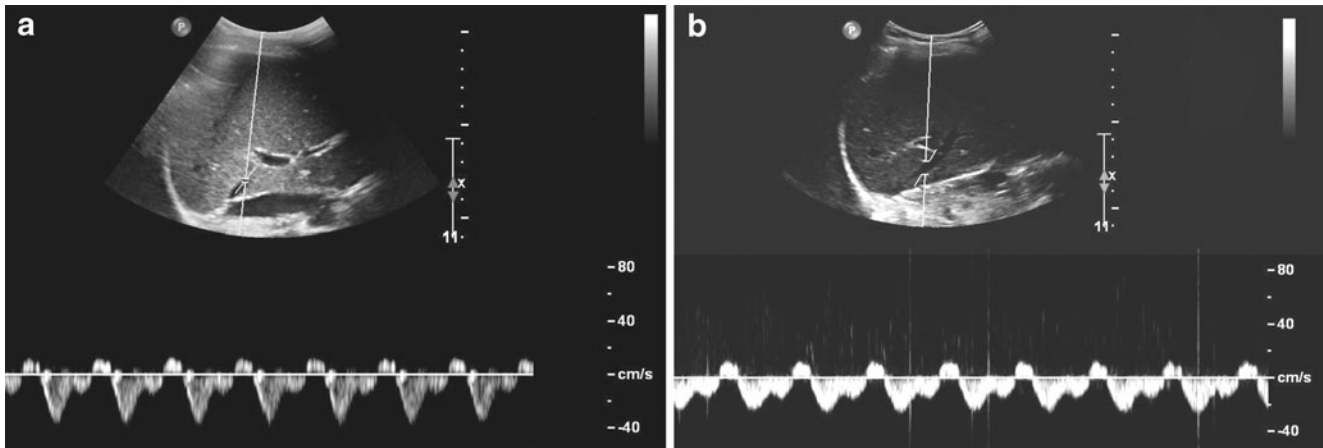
Spectral Doppler for hepatic vein transit time measurement. The spectral Doppler sample volume is placed on a hepatic vein before injection of the contrast agent, in this case sulphur hexafluoride-filled microbubbles (a), and the time when the signal
